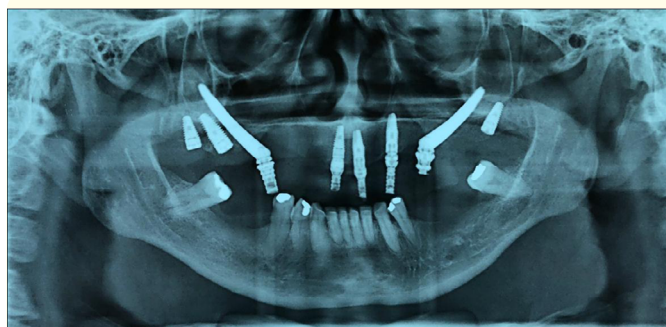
Panoramic radiograph showed the presence of bilateral zygomatic implants and 6 other implants in the maxilla.
